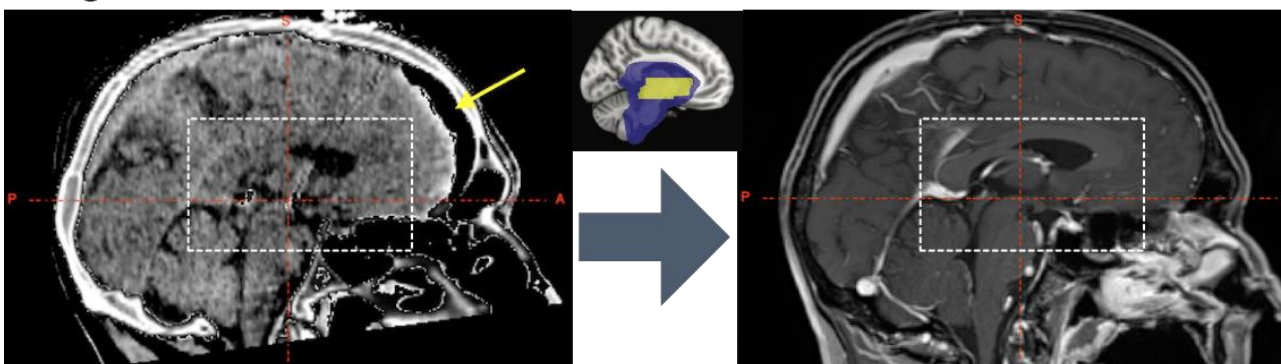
Brain shift correction approach. The top panel shows a whole-brain affine registration aligning a postoperative CT with frontal pneumocephalus (left) to a preoperative T1-weighted MRI (post gadolinium). Based on the pneumocephalus (yellow arrow), a nonlinear error results that is largest in frontal regions (at the site of the pneumocephalus) that may still be substantial in the regions of interest of DBS (figure 5). In the mid row, an additional refinement transform between the subcortical area delineated by the white dashed box is computed. Finally, in the third row, one or two additional refinement transforms between subcortical areas of interest are computed based on masks defined in (Schönecker et al., 2009). This approach gradually shifts the registration area away from the area nonlinearly distorted by pneumocephalus toward the subcortical regions of interest.
